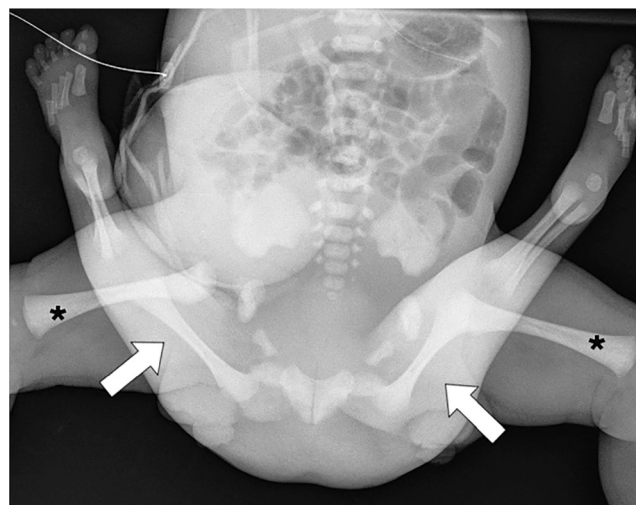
Radiograph of the neonatal ischiopagus parasiticus tetrapus. *White arrows* show cranially oriented, hypoplastic additional legs. The normally oriented legs are marked with *asterisks*
